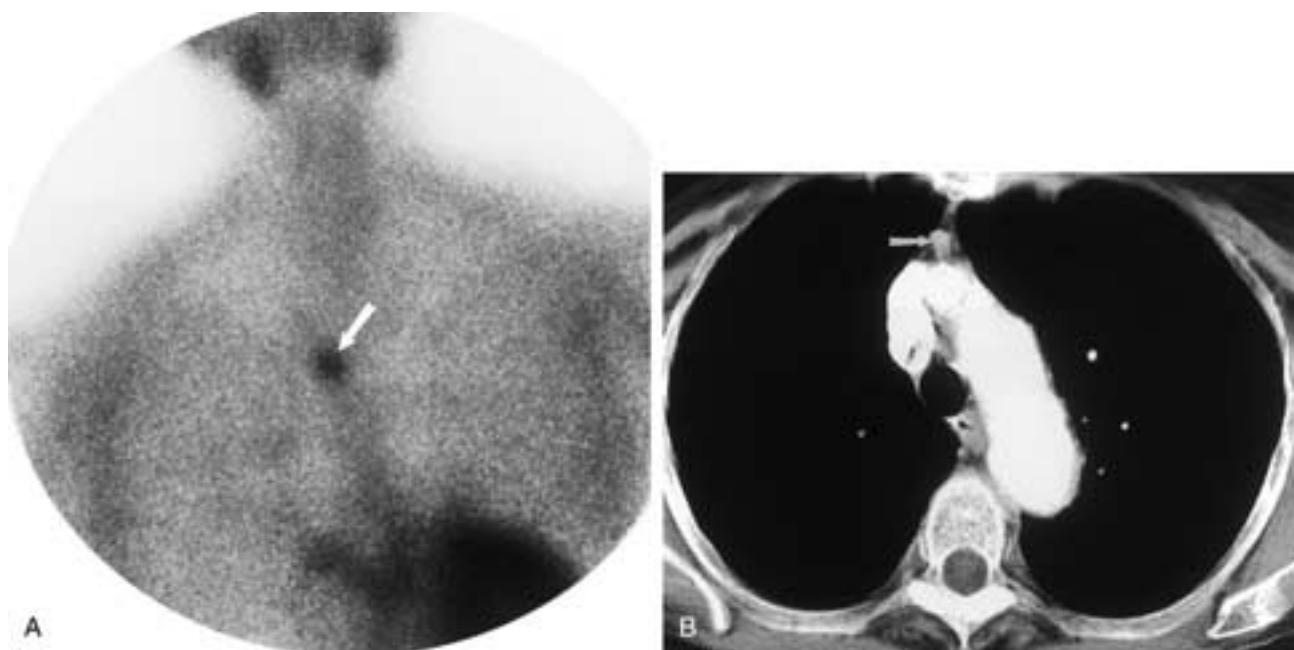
Ectopic parathyroid adenoma. A, Delayed image from a sestamibi scan shows increased uptake in a surgically proven ectopic parathyroid adenoma in the superior mediastinum (arrow). B, Enhanced chest CT scan shows the corresponding adenoma in the anterior mediastinum (arrow).
